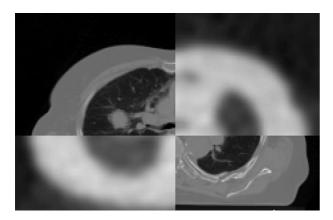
Matching of CT images with PET scan and tumour delineation facility.
